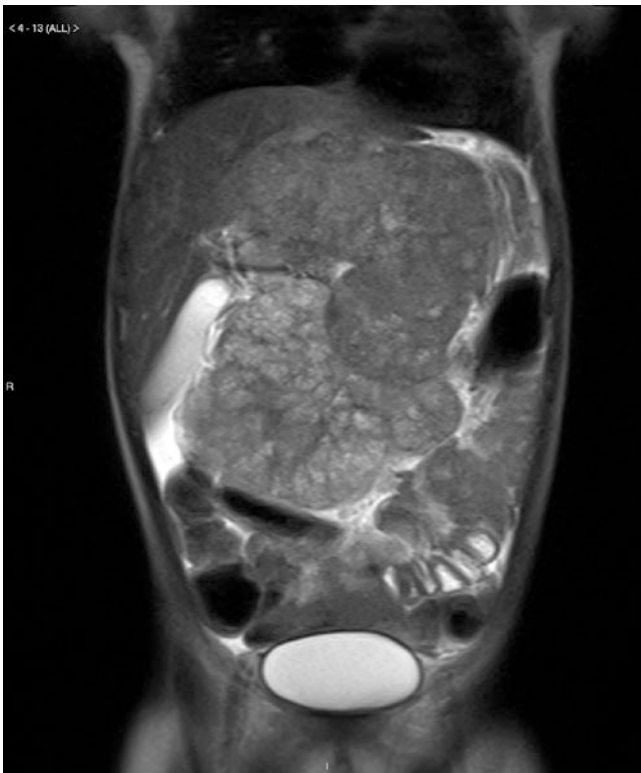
MRI scan showing an extensive tumour arising from the liver. Hepatoblastoma
